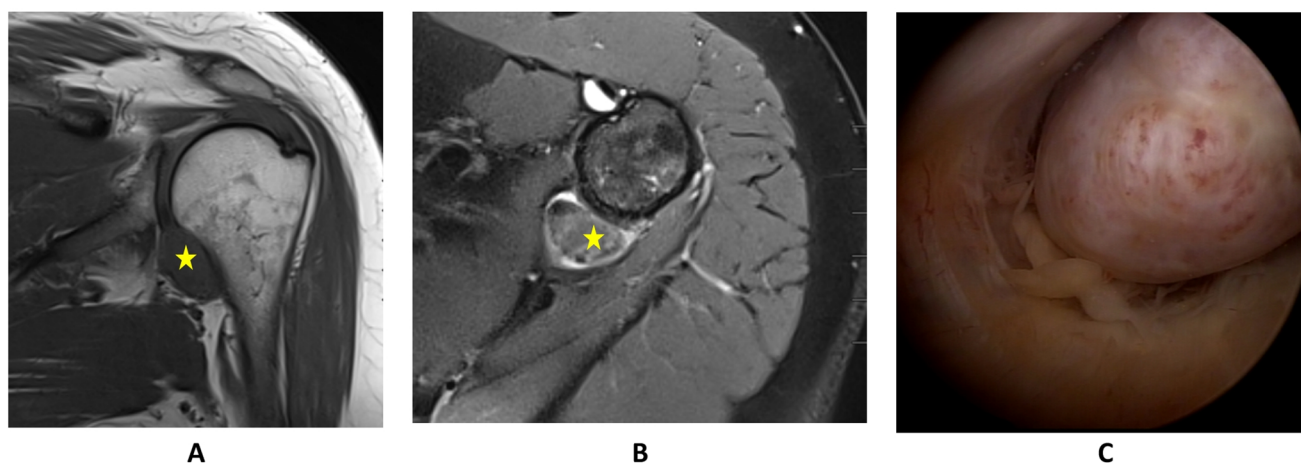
MRI scans and arthroscopic images of TGCT of the shoulder in patient 1. A: T1w coronal view of the left shoulder, depicting a mass in the lower recess. B: T2w axial view of the left shoulder, depicting a
